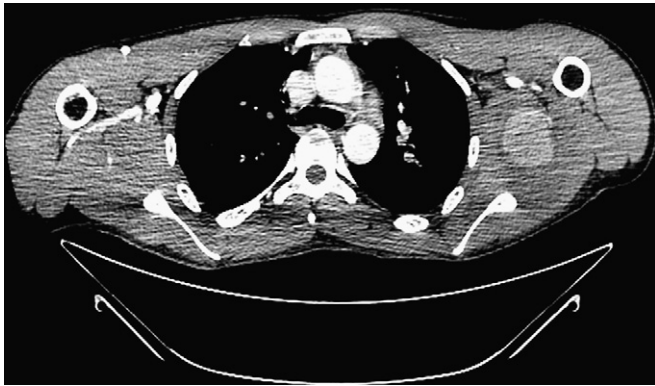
Postcontrast axial computed tomography images of the chest demonstrate an enhancing pseudoaneurysm within the left axilla.
